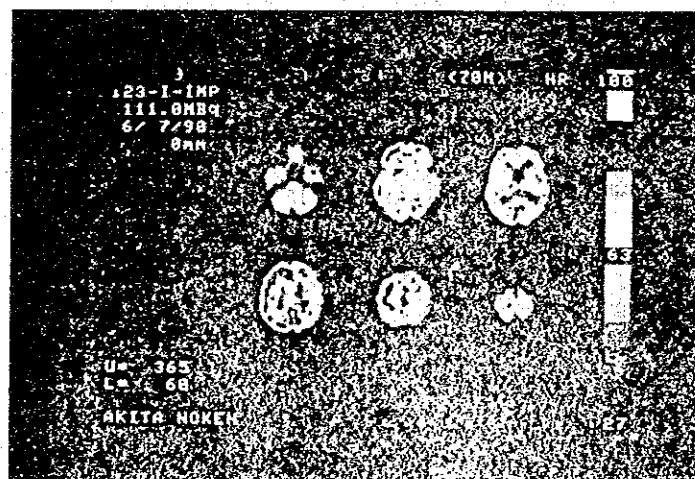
SPECT images using ^{123}I IMP
